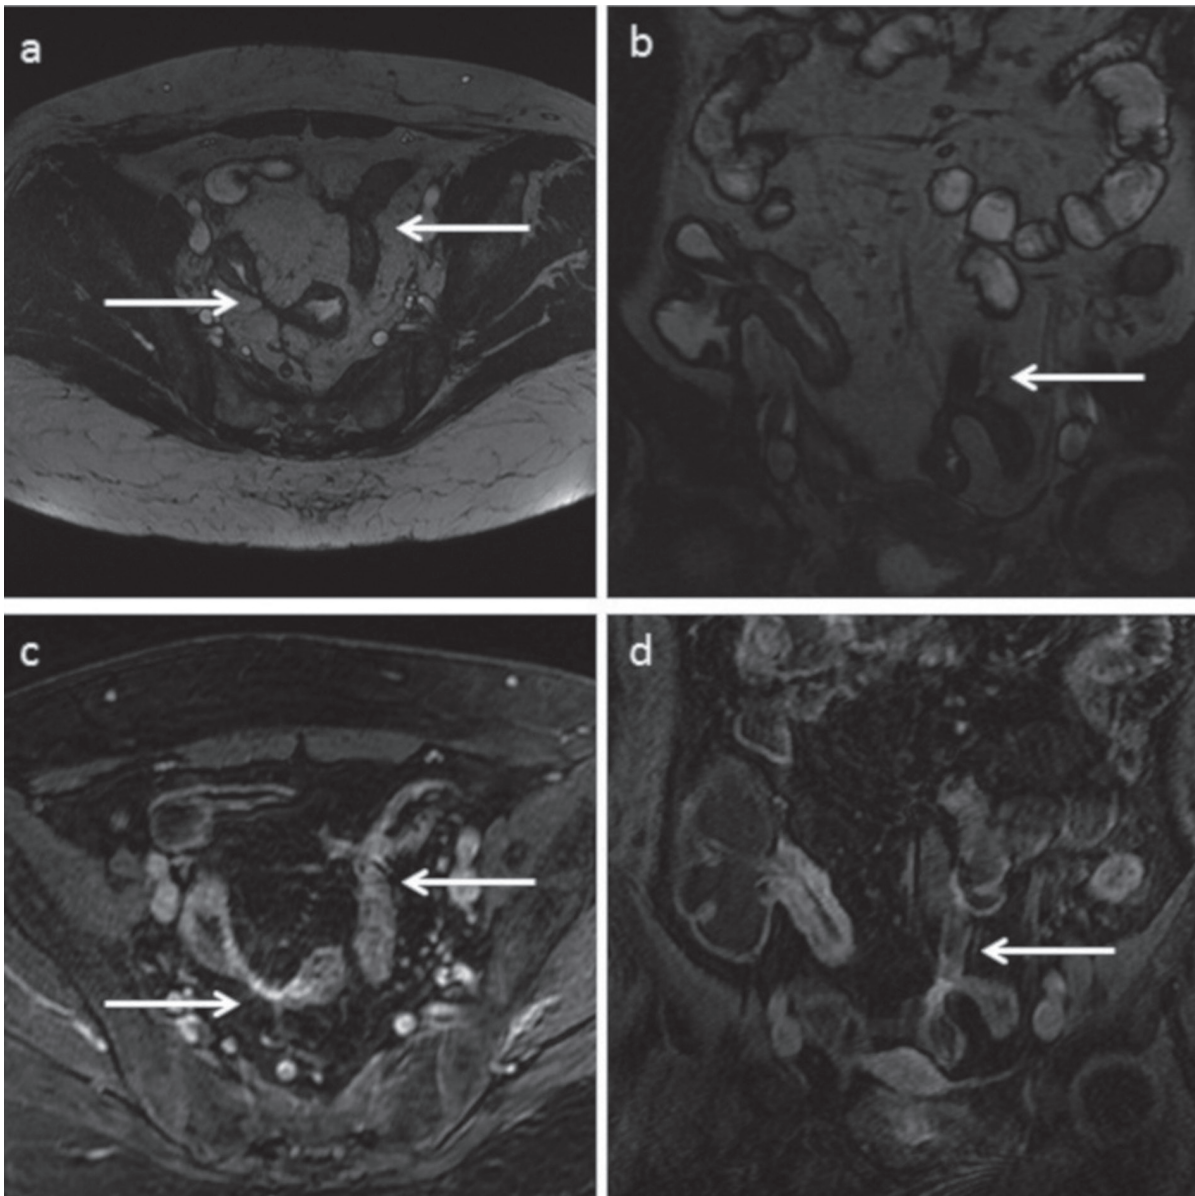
Example of enterocolic fistula formations (arrows) in a patient with CD for about 10 years. FIESTA images show «star sign» in axial (a) and coronal(b) planes and transmurals enhancement appears in axial (c) and coronal (d) T1-weighted fat-saturated images
